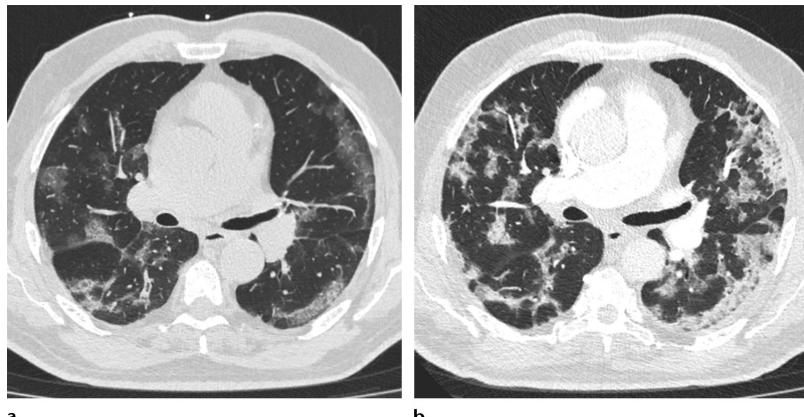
Transition from progressive stage to peak stage in a 69-year-old man with COVID-19. (a) Axial nonenhanced chest CT image (lung window) obtained at hospital admission shows bilateral areas of ground-glass opacities and crazy-paving appearance. (b) Axial contrast-enhanced chest CT image (lung window) obtained after 7 days shows progression from ground-glass opacities to multifocal organizing consolidation.
